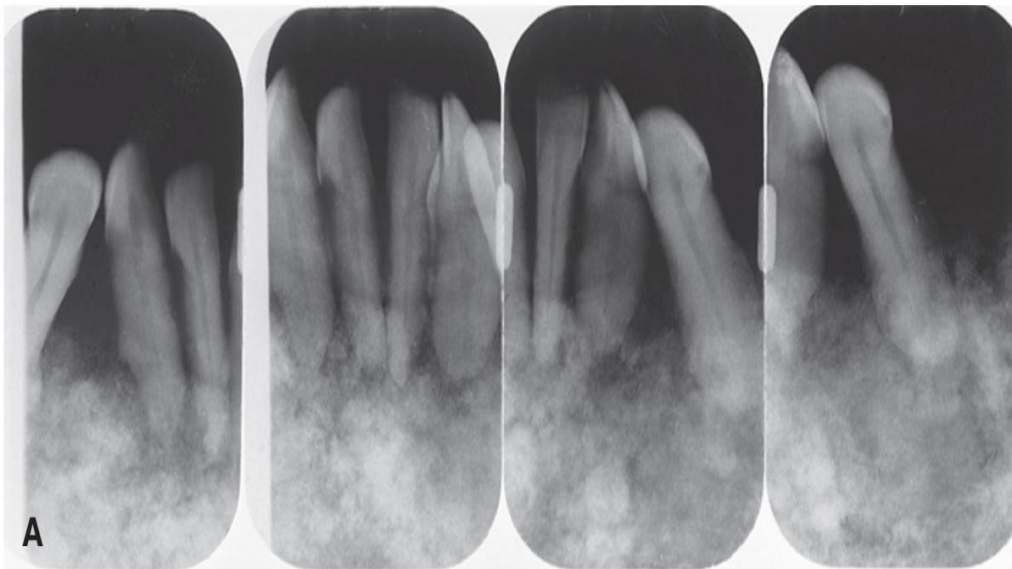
Periapical and occlusal images of Paget disease of bone showing multiple radiopaque masses in the mandible with a cotton-wool appearance (A) and mandibular expansion (B). Note maintenance of the thin cortices on the occlusal image.
